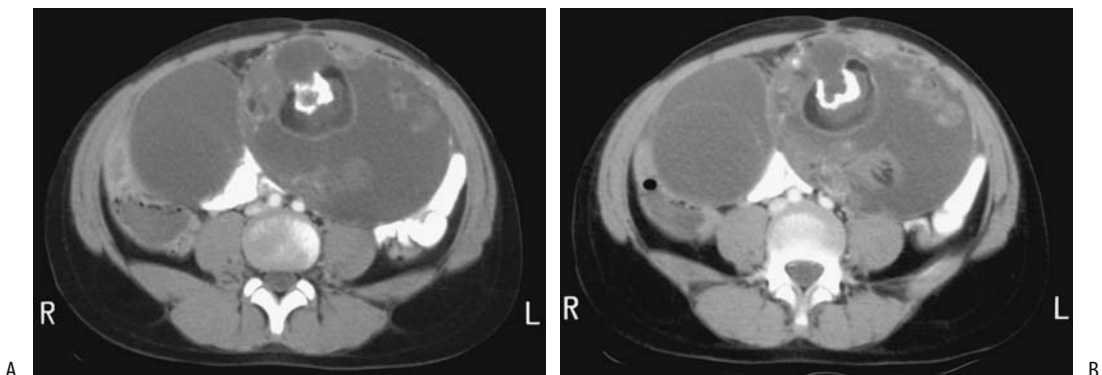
Ovarian germ cell tumor with crossover syndrome in a 7-year-old girl with pain and precocious puberty. A,B: Two CT images show bilateral complex, cystic ovarian tumors with left one containing calcifications. The right ovary was stimulated by the left ovarian tumor. (Courtesy of Luann Teschmacher, M.D., University of Rochester.)
